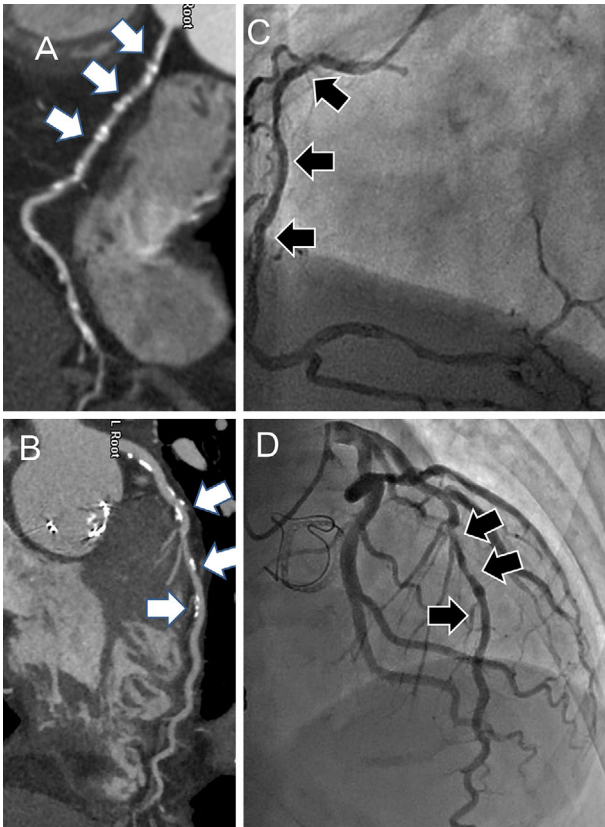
Typical images of coronary arteries with severe calcifications (patients' coronary calcium score almost 2,300) on 320-slice CT without MBIR (A, white arrow) and with MBIR (B, white arrow) and invasive coronary angiography of the same patient (C and D, black arrows). The stenosis in the segments with severe calcifications was complex, and the calcified stenotic lesion was over-diagnosed as significant stenosis (A, white arrows) with invasive coronary angiography regarded as a reference standard (C, black arrows). Because the blooming artifacts of calcification of the coronary artery were suppressed, and significant stenosis was correctly ruled out in the segments with severe calcifications on CT (B, white arrows) with invasive coronary angiography regarded as a reference standard (D, black arrows).
